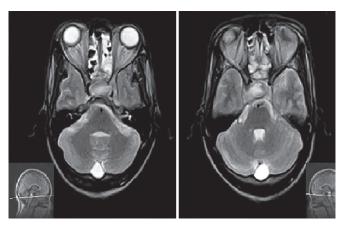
T2-weighted MRI image showing hyperintense lesion
